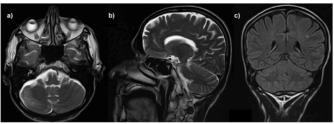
MRI repeated at 8 weeks after stopping metronidazole showed resolution of hyper-intense signals of the dentate nuclei in T2weighted axial (a), sagittal (b), and FLAIR images (c).
